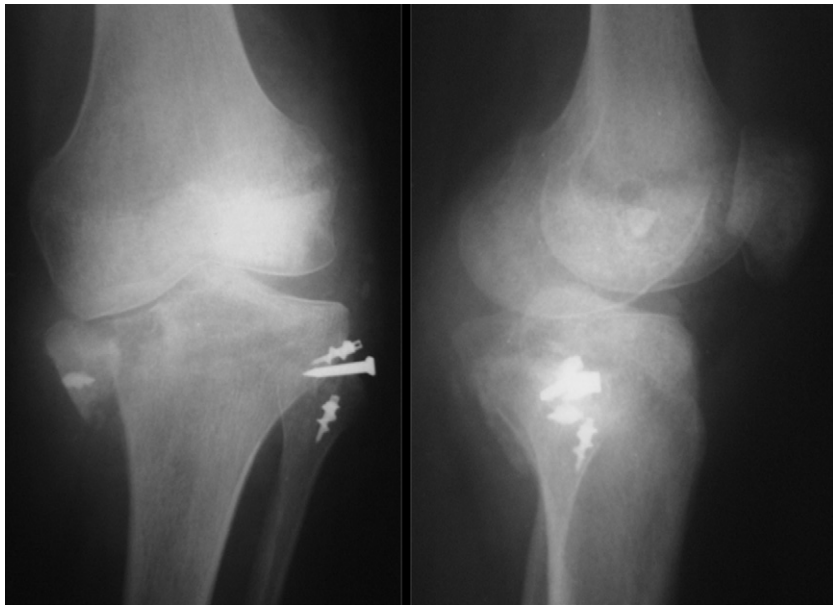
Radiographs showing the failure of the reconstruction following trauma.
